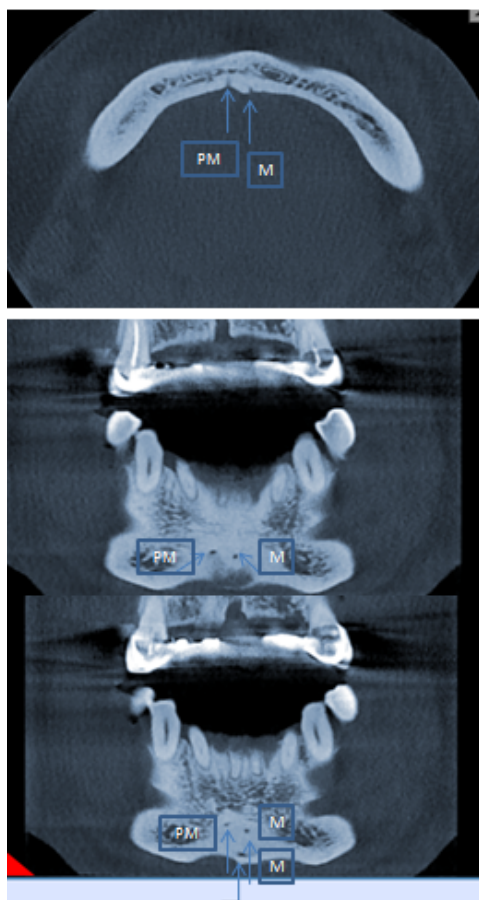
Median and paramedian lingual foramen in axial and coronal section of CBCT
